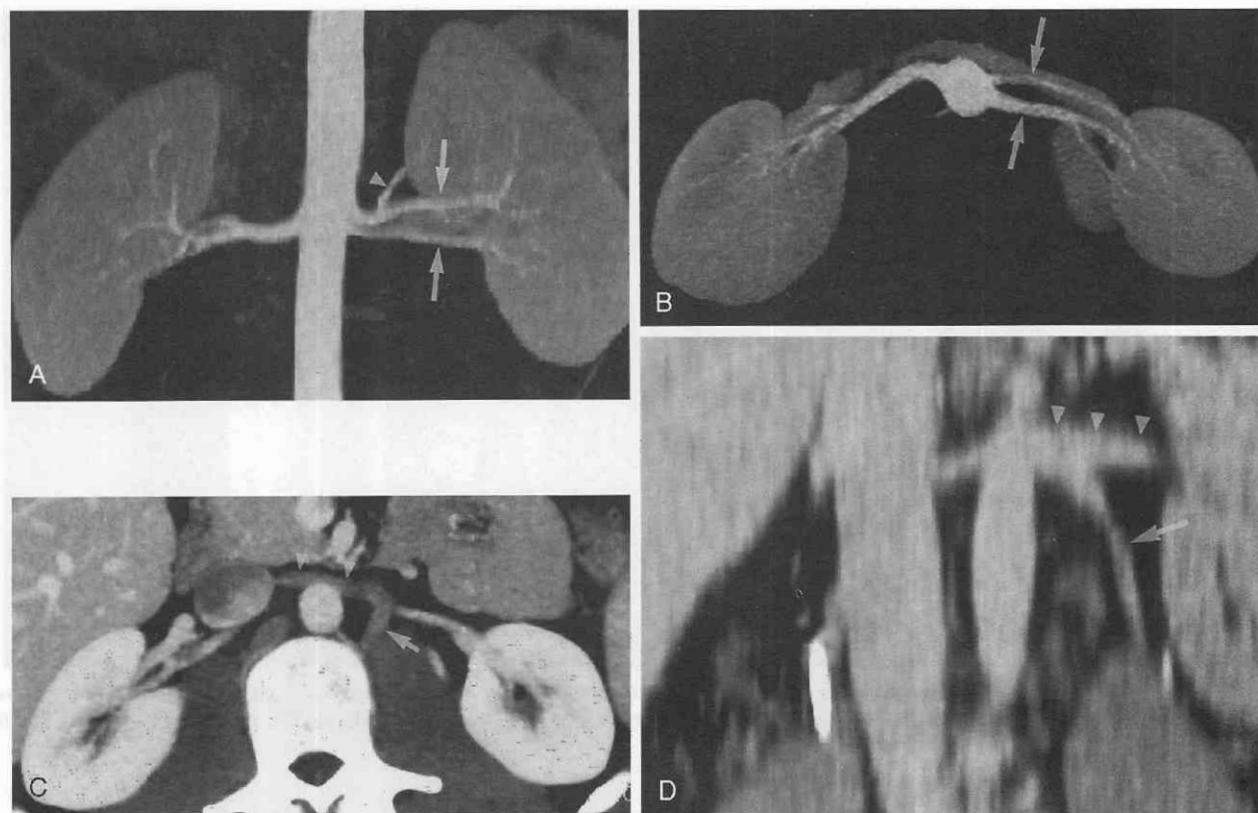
Renal donor evaluation. The multislice helical CT examination has three or more phases. In this potential donor, the arterial phase coronal (A) and axial (B) maximum-intensity projection images demonstrate two left renal arteries (arrows) and an early branching artery to the upper pole (arrowhead). C, The nephrographic phase disclosed a lumbar vein (arrow) merging with the left renal vein (arrowheads) as shown on an axial maximum-intensity projection image. D, On an oblique multiplanar reformat, a left gonadal vein (arrow) is shown merging with the left renal vein (arrowheads).
